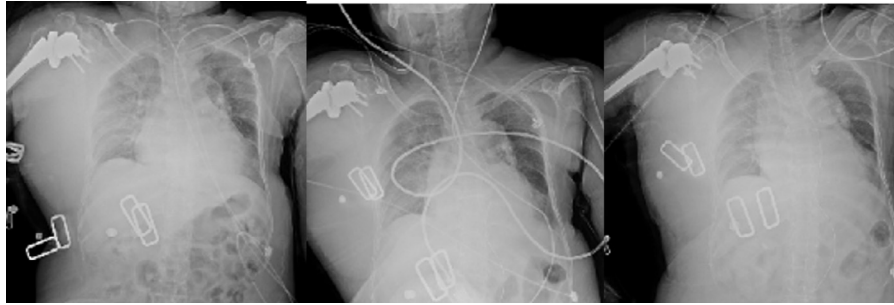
Serial chest X-ray showing a large hematoma around the chest wall.
